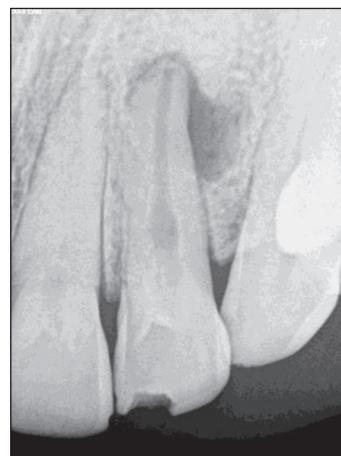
Radiograph reveals dens invaginatus with internal resorption and periapical pathosis relation to 22
